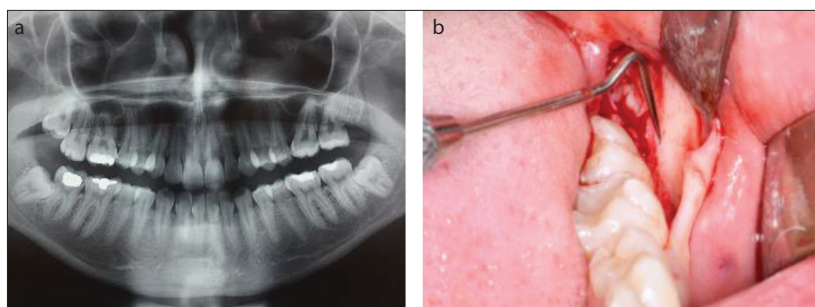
Preoperative X-ray and intraoperative insight: a – mandibular lower left third molar with Pell-Gregory II-b type of the impaction; b – bucco-distal bone is present preoperatively
